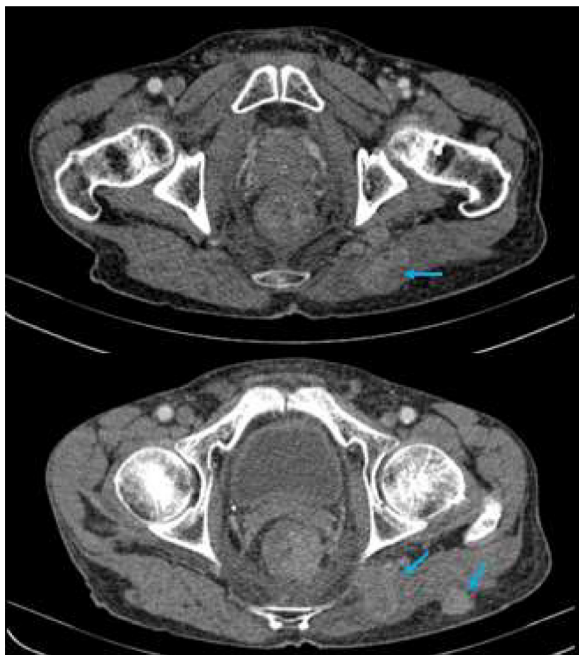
Axial postcontrast CT scan sections displaying nodular metastatic lesions in the left buttock involving the gluteus maximus and gluteus medius (blue arrows).
